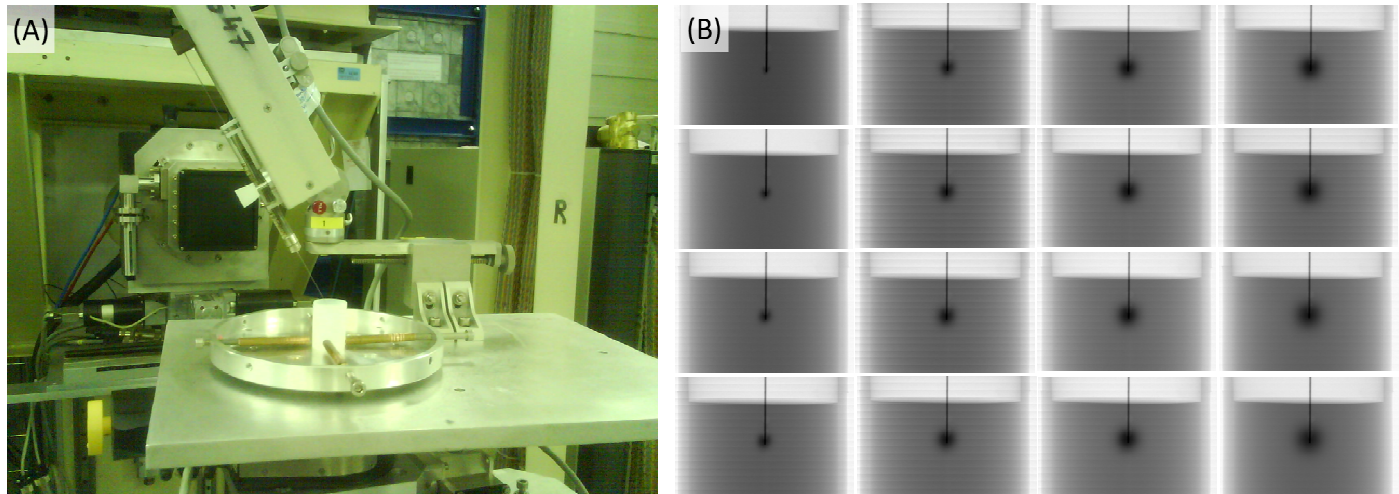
(A) Picture of the experimental setup. (B) Radiographic images of a gel during a 40 minute infusion of 20  $\mu$ L of an iodine contrast agent, taken every three minutes (from 2 to 49 min ; reading from top to bottom, and from left to right).
